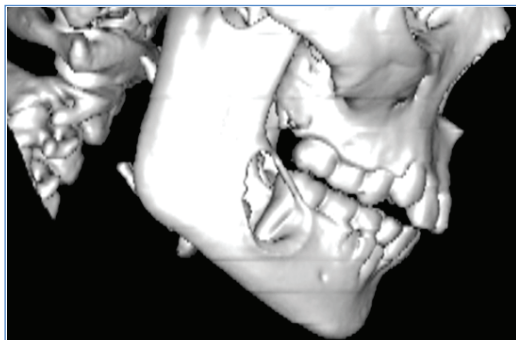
CT 3D reconstruction
